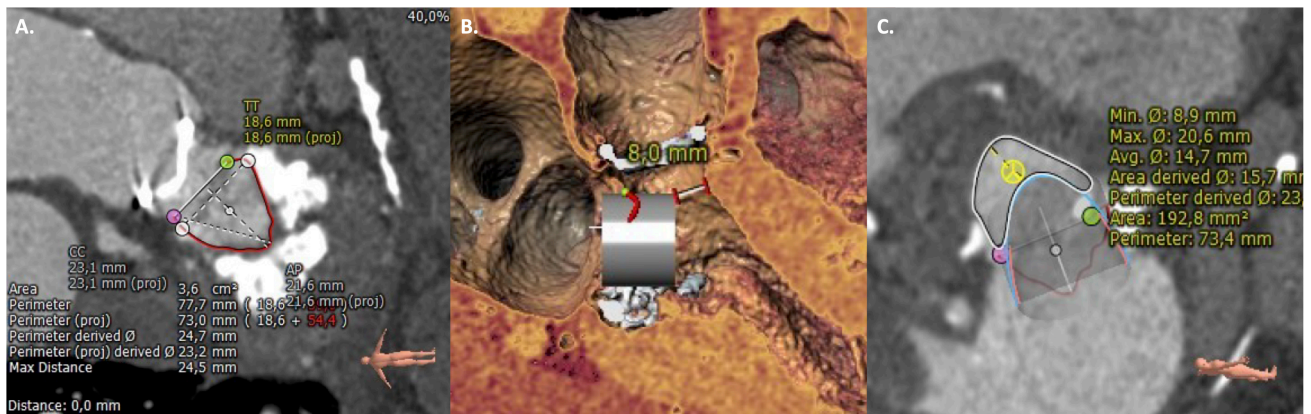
Valve-in-mitral annular calcification (ViMAC) procedural planning. Contrast-enhanced computed tomography (CT) scan depicting a posterolateral 180° extension mitral annular calcification (A). Three-dimensional virtual valve implantation (B). Neo-left ventricular outflow tract (LVOT) area based on virtual valve position (C). Adapted from: Barreiro-Perez M, *et al.* J. Clin. Med 2021, 10: 5973 [4].
